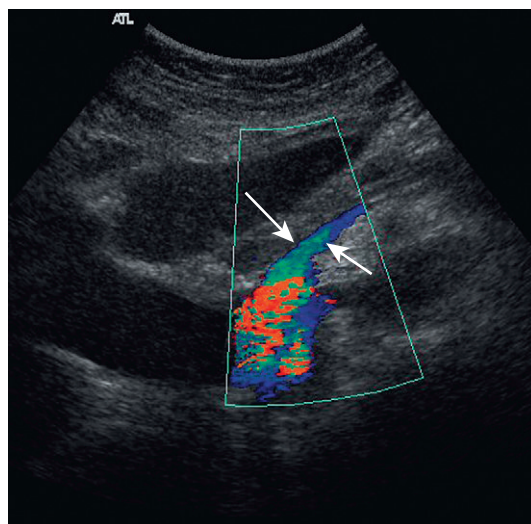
Colour Doppler image of a portocaval shunt. The portal vein (arrows) has been surgically anastomosed to the inferior vena cava.
